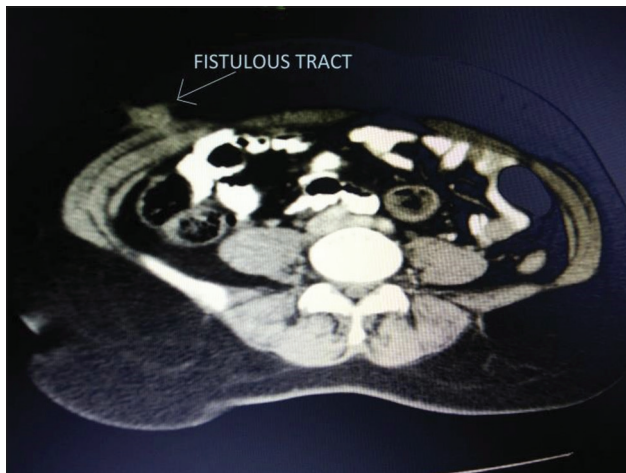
CT scan of fistulous tract
